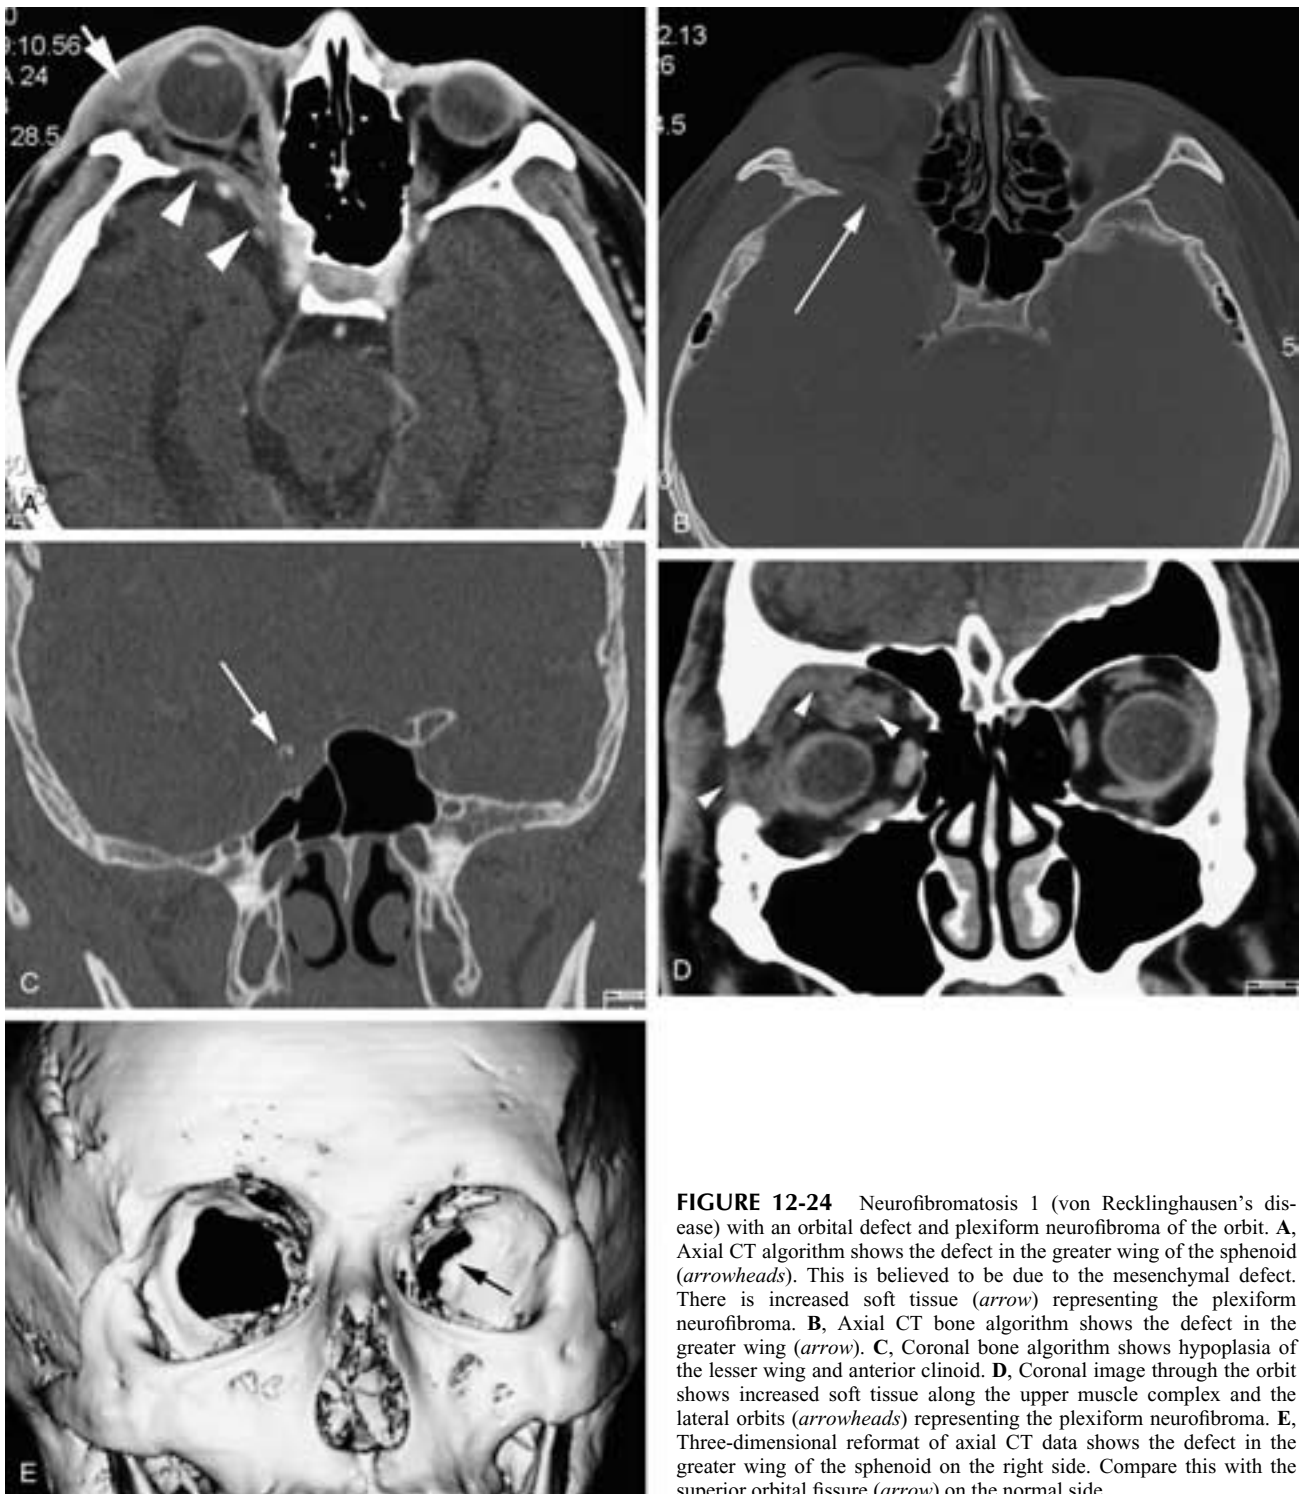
Neurofibromatosis 1 (von Recklinghausen's disease) with an orbital defect and plexiform neurofibroma of the orbit. A, Axial CT algorithm shows the defect in the greater wing of the sphenoid (*arrowheads*). This is believed to be due to the mesenchymal defect. There is increased soft tissue (*arrow*) representing the plexiform neurofibroma. B, Axial CT bone algorithm shows the defect in the greater wing (*arrow*). C, Coronal bone algorithm shows hypoplasia of the lesser wing and anterior clinoid. D, Coronal image through the orbit shows increased soft tissue along the upper muscle complex and the lateral orbits (*arrowheads*) representing the plexiform neurofibroma. E, Three-dimensional reformat of axial CT data shows the defect in the greater wing of the sphenoid on the right side. Compare this with the superior orbital fissure (*arrow*) on the normal side.
